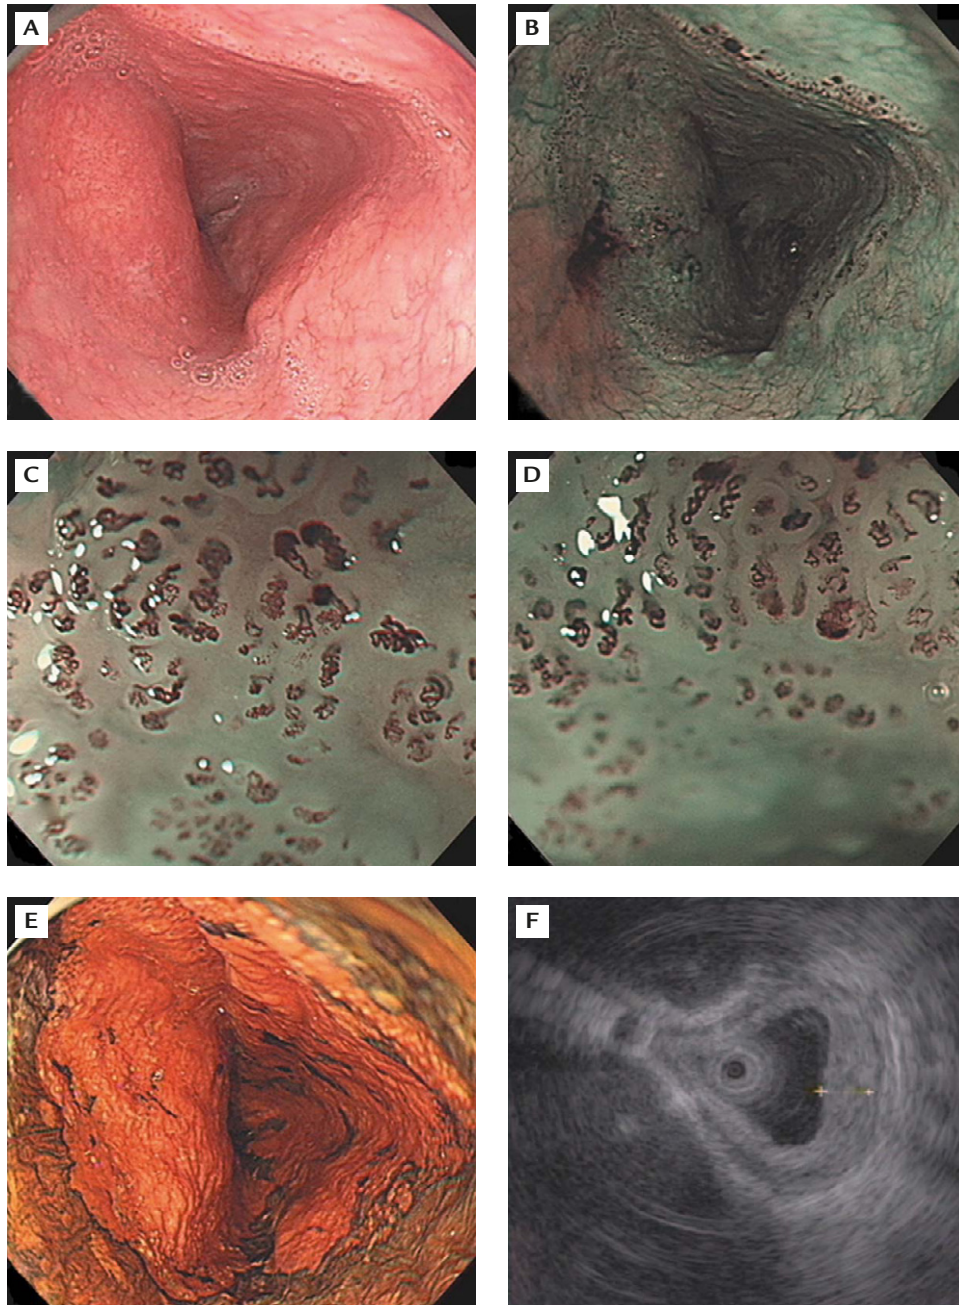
Endoscopic views of the esophagus. (A) White-light conventional endoscopy shows mildly hyperemic mucosa. (B) Narrow-band imaging endoscopy reveals circumferential brownish discoloration. (C and D) Magnifying endoscopy with a narrow-band imaging system shows intrapapillary capillary loop (IPCL) type V_N . (E) Lugol's chromoendoscopy shows a circumferential Lugol-voiding area. (F) An endoscopic ultrasound discloses thickening of the esophageal wall with involvement of the muscularis propria with T2 invasiveness.
